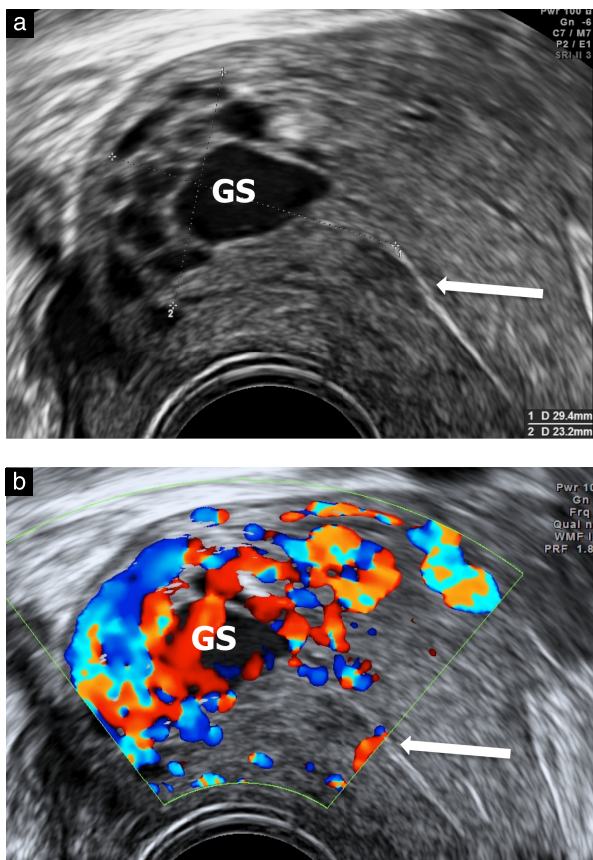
Longitudinal section of uterus on grayscale (a) and color Doppler (b) imaging, showing endometrial cavity (arrow) and gestational sac (GS) embedded deeply in myometrium of upper left of cavity, in keeping with partial intramural pregnancy. Calipers in (a) indicate complete pregnancy tissue. On color Doppler examination (b), GS was highly vascularized.
